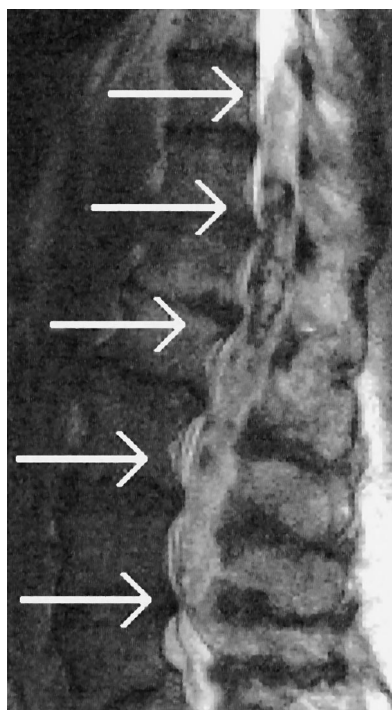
Sagittal magnetic resonance image showing the large extension of the hematoma, as well as its heterogeneity.
